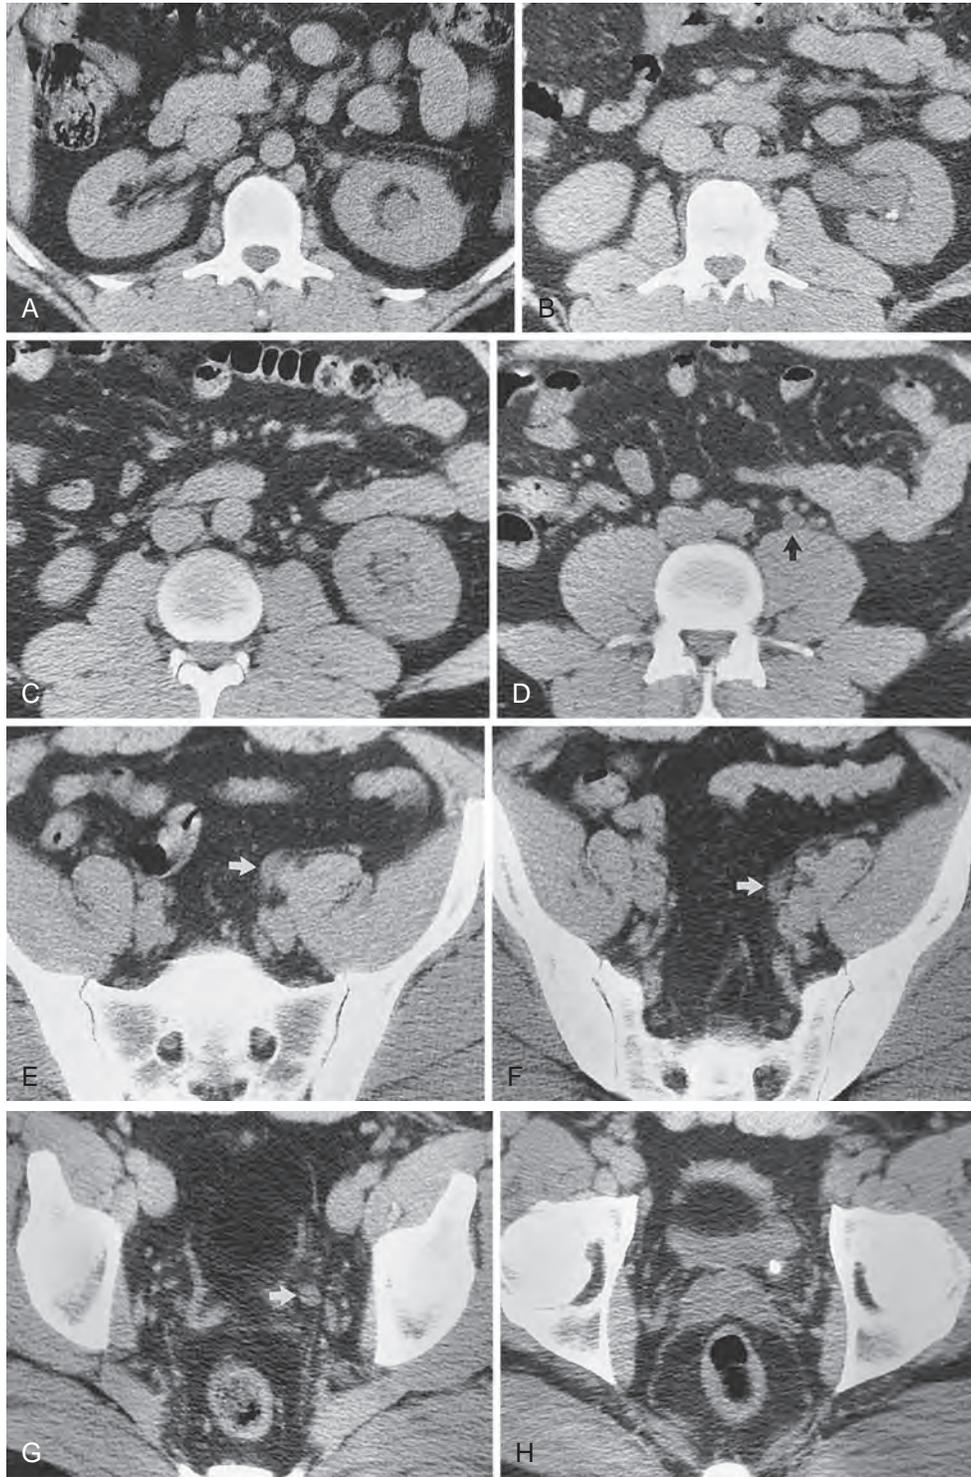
CT of the abdomen and pelvis in patient with an obstructing ureteral stone at the level of the ureterovesicle junction. (A) Level of the left upper pole. Mild renal enlargement, caliectasis, and perinephric stranding are apparent. (B) Level of the left renal hilum. Left pyelectasis with a dependent stone, mild peripelvic and perinephric stranding, and a retroaortic left renal vein are shown. (C) Level of the left lower pole. Left caliectasis, proximal ureterectasis, and mild periueteral stranding are present. (D) Level of the aortic bifurcation. The dilated left ureter (*arrow*) has lower attenuation than do nearby vessels. (E) Level of the upper portion of the sacrum. A dilated left ureter (*arrow*) crosses anteromedial to the common iliac artery. (F) Level of the midsacrum. A dilated left ureter (*arrow*) is accompanied by periueteral stranding. (G) Level of the top of the acetabulum showing a dilated pelvic portion of the left ureter (*arrow*). (H) Level of the ureterovesical junction. The impacted stone with a “cuff” or “tissue rim” sign that represents the edematous wall of the ureter. (Reprinted from Talner LB, O’Reilly PH, Wasserman NF: Specific causes of obstruction. In Pollack HM, et al., eds: *Clinical urography*, ed 2, Philadelphia, 2000, Saunders.)
